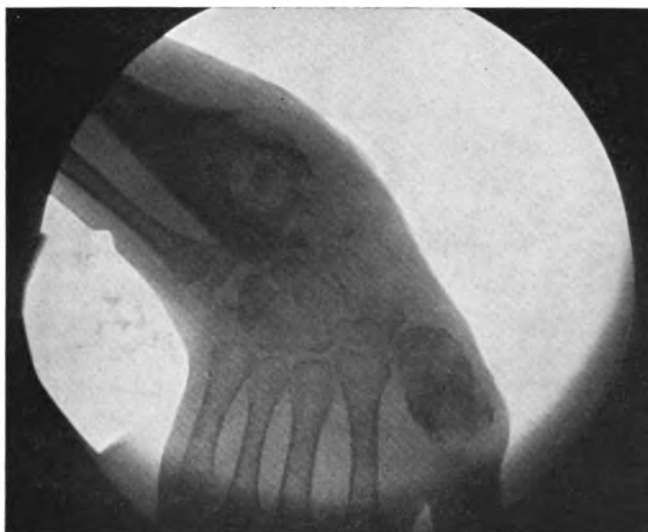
Gumma of the radius and of the first metatarsal bone. (Radiograph by Mr. Brush, Metropolitan Hospital.)
